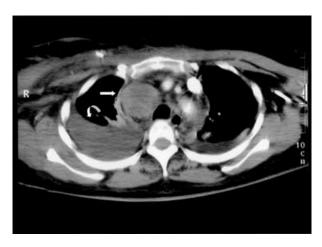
Contrast-enhanced computed tomography scan showing the hematoma in the region of the right superior vena cava (straight arrow) and the right pleural effusion (curved arrow).
